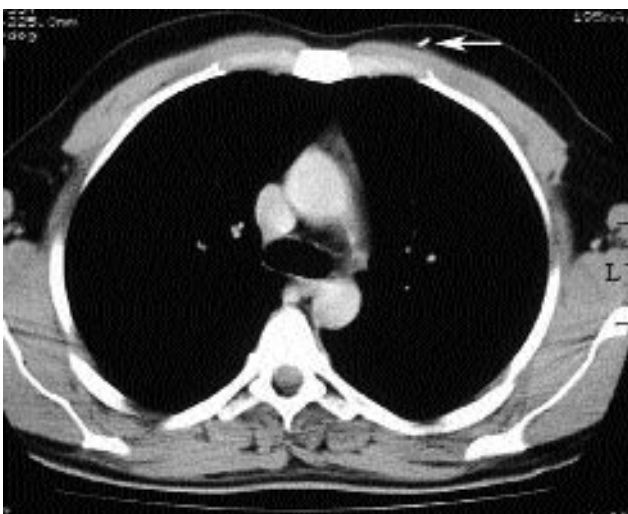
A chest CT scan showing subcutaneous location of the needle.
